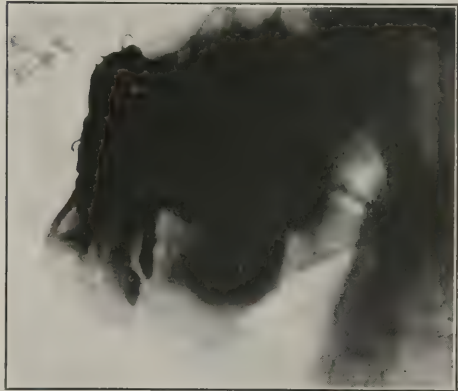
Case 3: Radiograph showing loss of substance, posterior root of first molar projecting into area of fracture.
